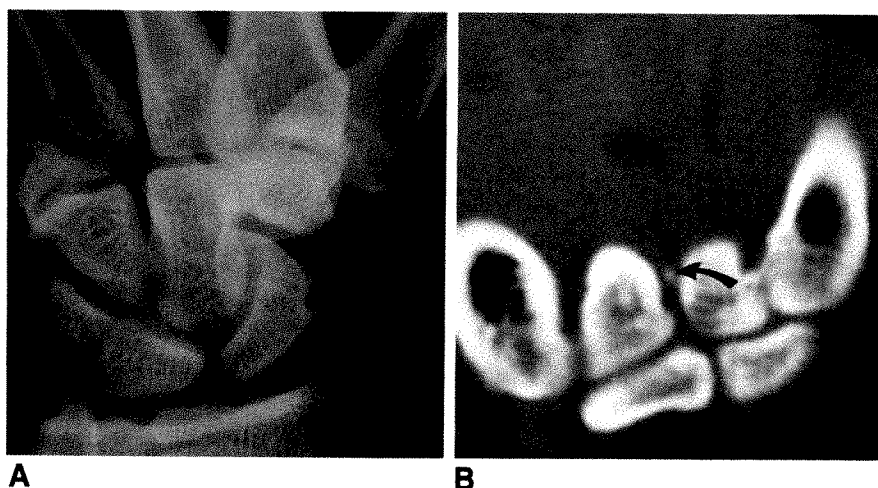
Occult metacarpal fractures are difficult to show radiographically.
